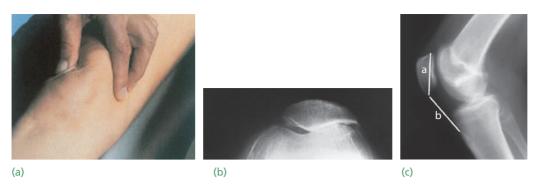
Chondromalacia of the patella There is no pathognomonic feature on which to base the diagnosis of chondromalacia, but several signs are suggestive. (a) Hold the patella against the femoral condyles and ask the patient to tighten the thigh muscles; even in normal people this may be uncomfortable, but patients with chondromalacia experience sudden acute pain in the patellofemoral joint. (b) A 'skyline' X-ray with the knee in partial flexion may show obvious tilting of the patella. (c) In the lateral X-ray, with the knee flexed to 45°, the lengths of the patella and the patellar ligament are normally about equal (a ratio of 1:1); in patella alta the ratio is less than 1:1.
